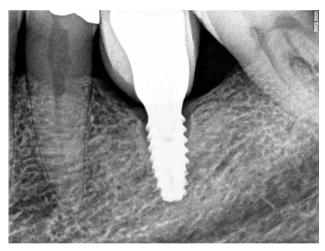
Case 3: Initial periapical x-ray.
